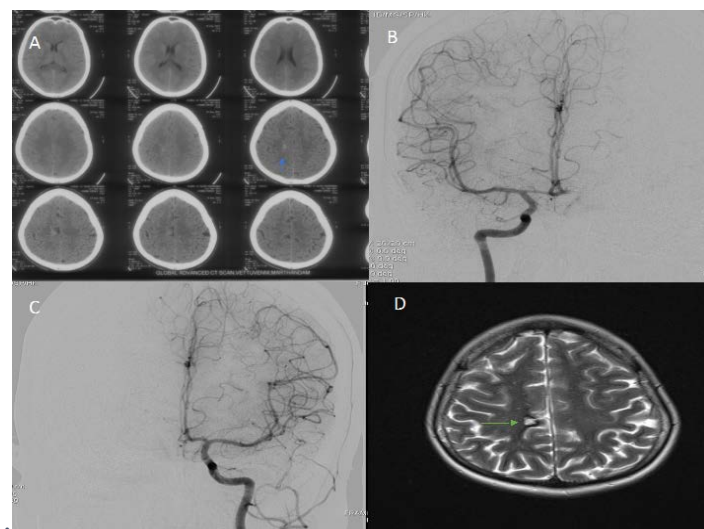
A shows peripheral/ sulcal SAH in medial frontal region; B & C showing normal right and left ICA injection on DSA; follow up MRI T2 sequence shows well defined T2 hyperintense lesion with surrounding hypointense rim suggestive of cavernoma (arrow).
